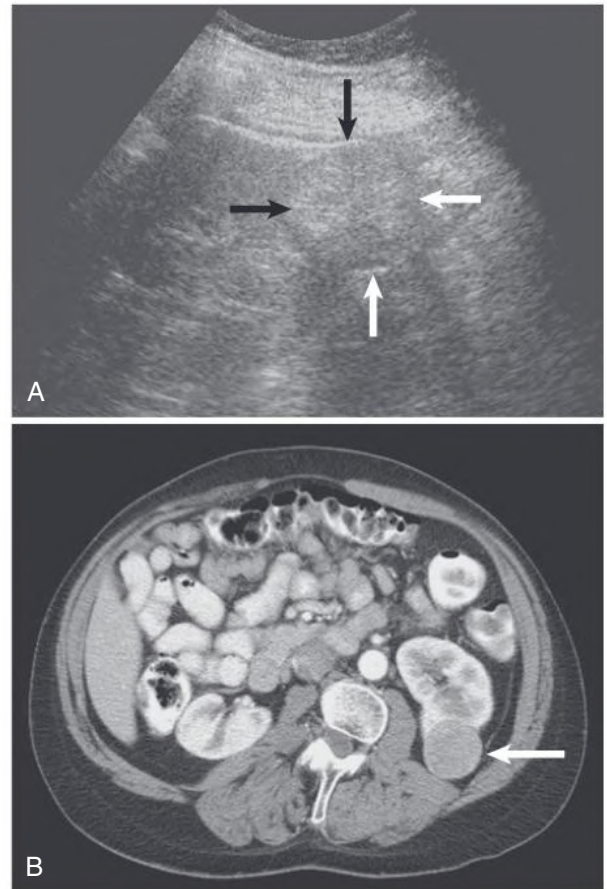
Evaluation of Kidney Mass. (A) Sagittal ultrasound image shows large hyperechoic mass arising from the lower pole (arrows). (B) Corresponding contrast-enhanced computed tomography scan shows kidney cell carcinoma (arrow).
